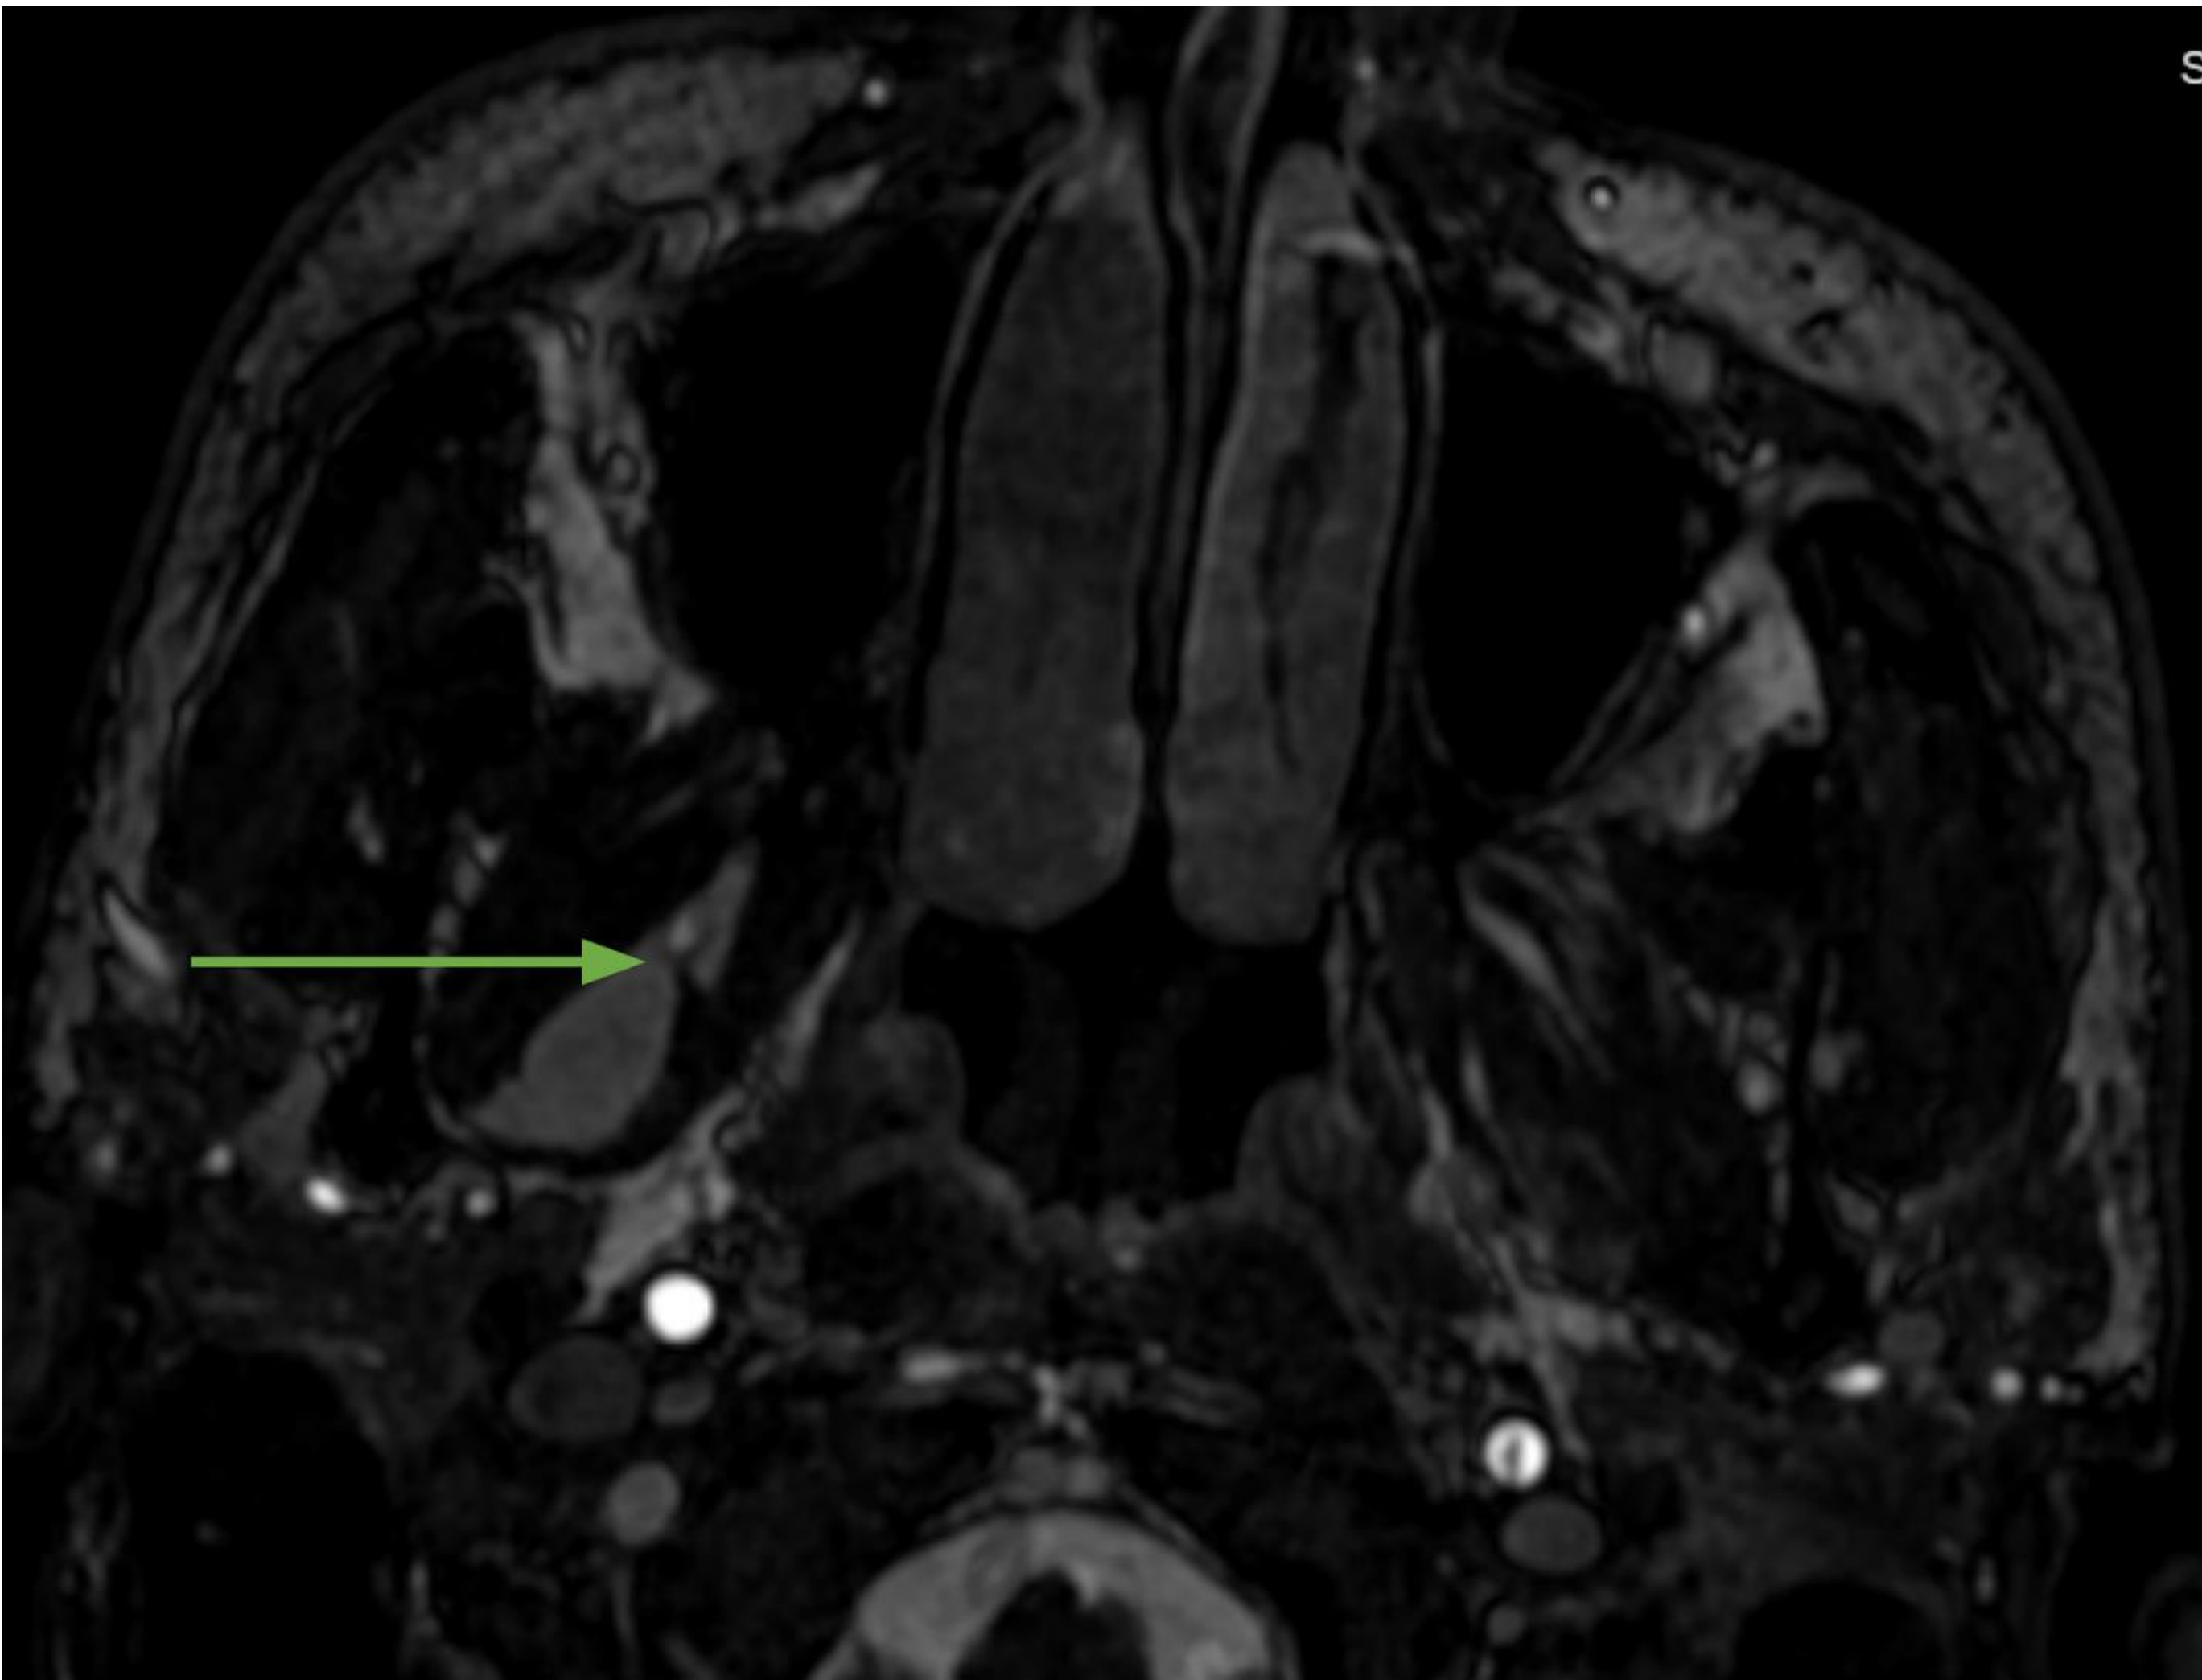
Pre-operative axial FIESTA MRI demonstrating area of internal maxillary artery compression on V3 (green arrow).
